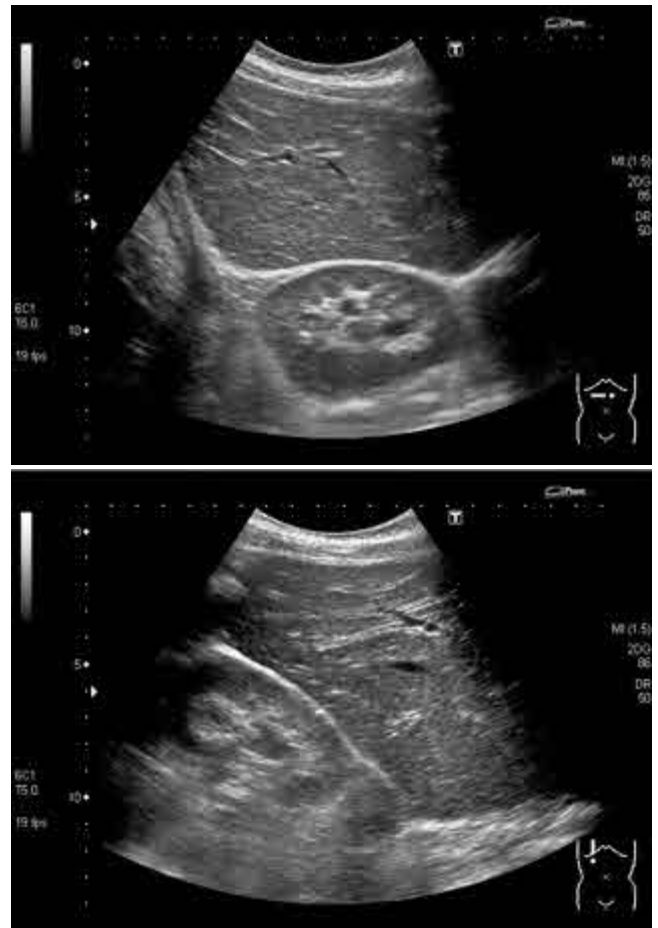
Ultrasound showing a right kidney normal in size and appearance but located above the right lobe of the liver
